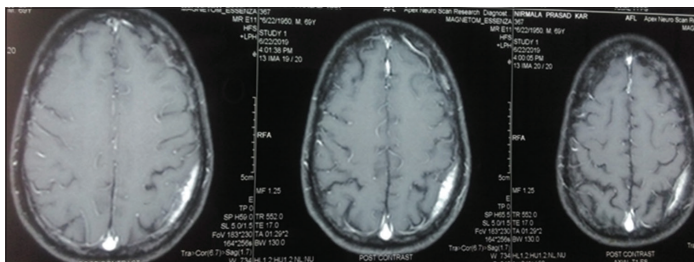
Magnetic resonance imaging brain T1+ contrast sequence showing a dural enhancing lesion in the posterior parietal region
